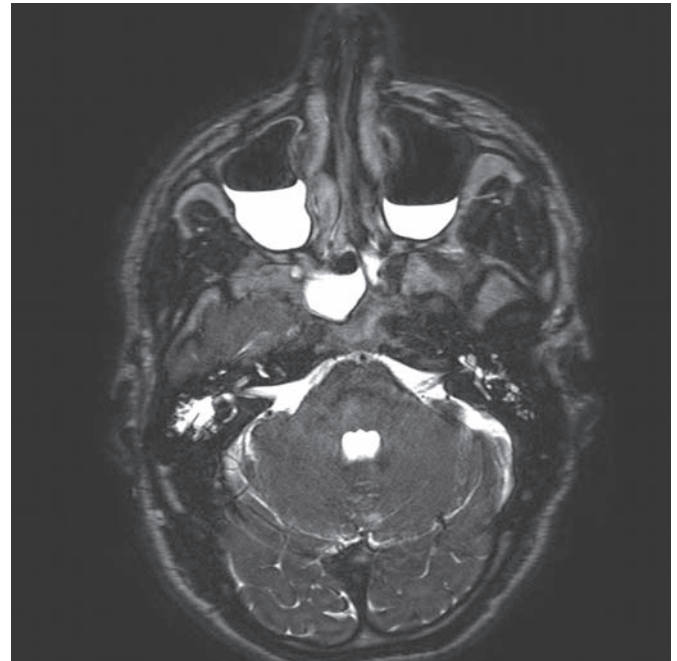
MRI image at the level of the Eustachian tube (arrows) and upper end of maxillary sinuses.
